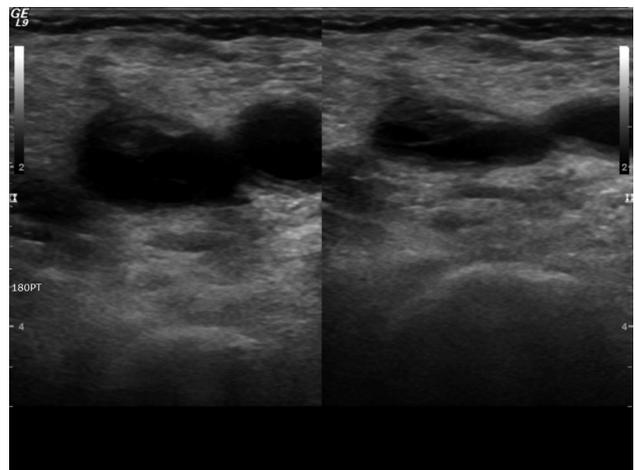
Lower extremity Doppler sonography with acute deep vein thrombosis from left common iliac and femoral vein to popliteal vein, and its distal branches.
